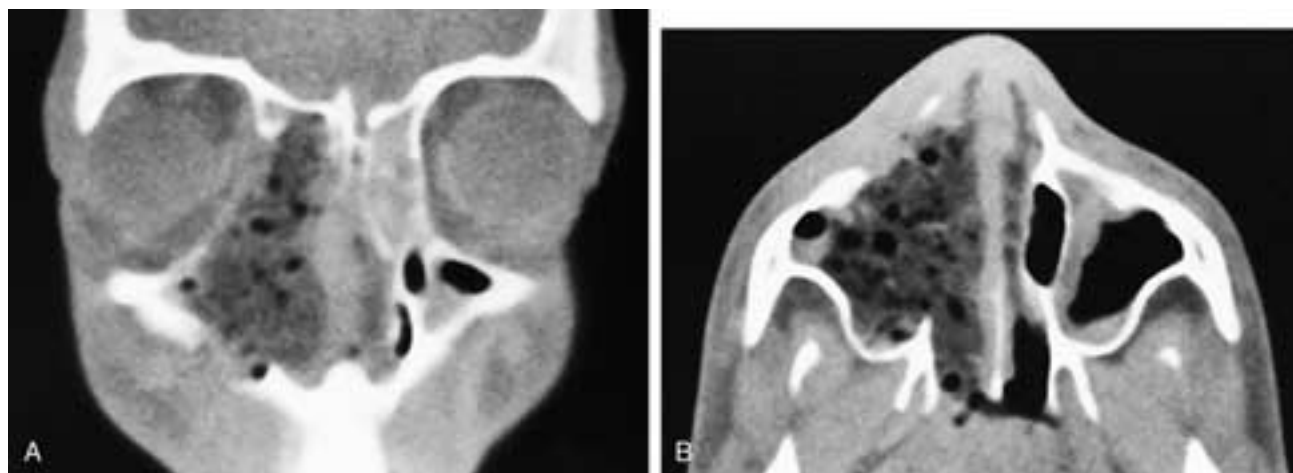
Coronal (A) and axial (B) CT scans show a patient who has had a right lateral rhinotomy. The postoperative cavity is filled with packing.
